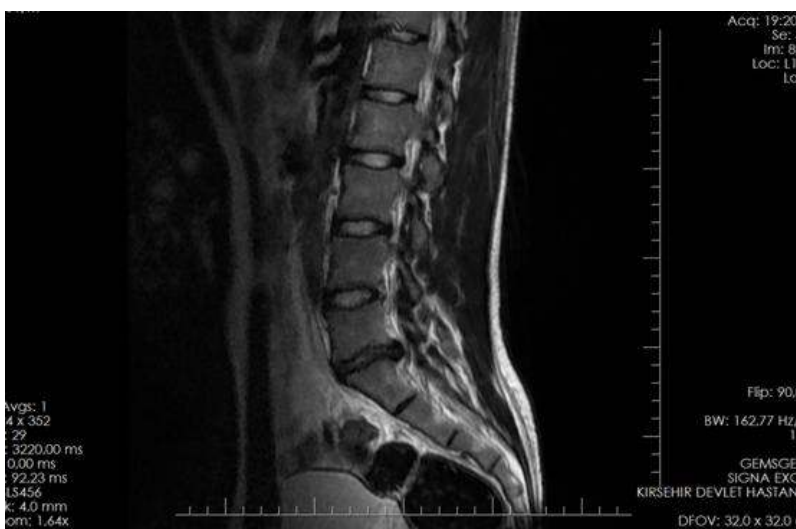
Magnetic resonance imaging: T2 weighted sagittal view L5-S1 disc protrusion (case 2)
